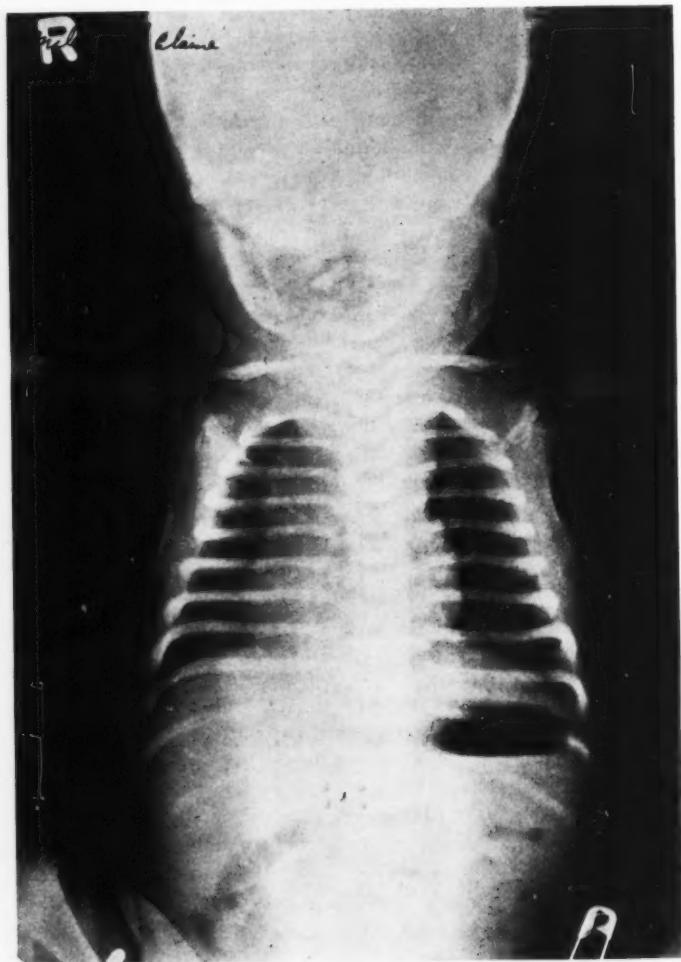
R. M. X-ray taken upon admission showing a grossly abnormal cardiac contour which probably represents thymic gland enlargement.
